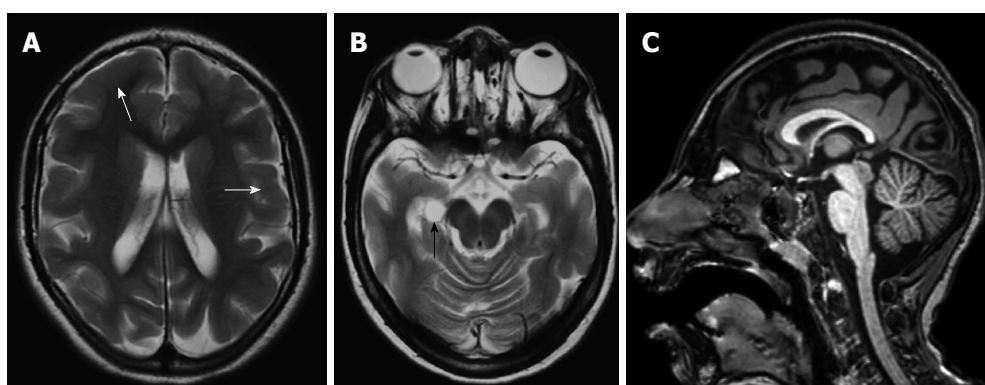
An 8-year-old girl with microlissencephaly. Axial T2-weighted images (A, B) show reduction in the number and depth of the sulcus, thickened cortex (white arrows) with choroidal fissure cyst (black arrow). Thinning of posterior parts of the corpus callosum is also seen on sagittal three-dimensional (3D) T1-weighted image (C).
